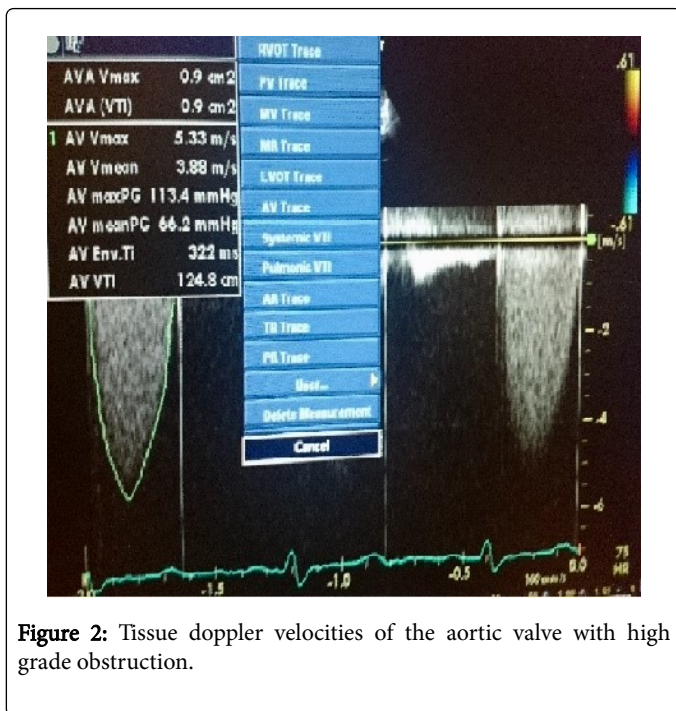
Tissue doppler velocities of the aortic valve with high grade obstruction.
